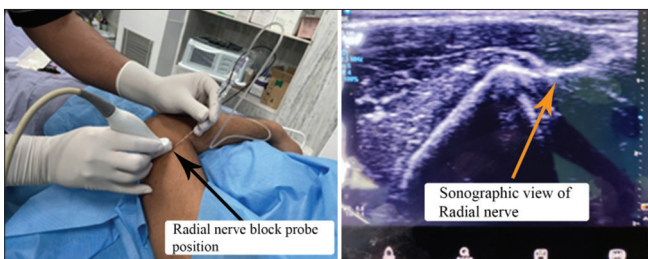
Probe position and corresponding sonographic view for radial nerve block. Ultrasound probe was placed over the lateral aspect of the arm over the lateral epicondyle. The needle was inserted in-plane from lateral to medial direction, and 6 mL of solution was deposited in between brachialis and brachioradialis from where radial nerve emerges.
